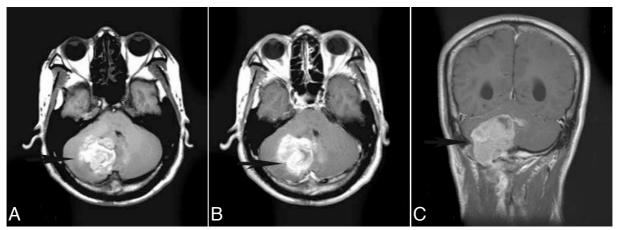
Noncontrast axial T1-weighted MRI of the brain (A) demonstrates heterogenous high signal intensity in the right cerebellum. Postcontrast axial T1-weighted MRI (B) shows the new enhanced area. Coronal T1-weighted MRI with contrast (C) shows tumor with skull base invasion and downward extension to upper neck.
